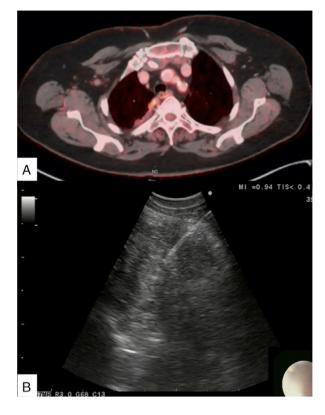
(A) Positron emission tomography-computed tomography (PET-CT) showing thickened and metabolic active right pleural lesions close to the oesophagus. (B) EUS-B-FNA of the pleural lesion.
